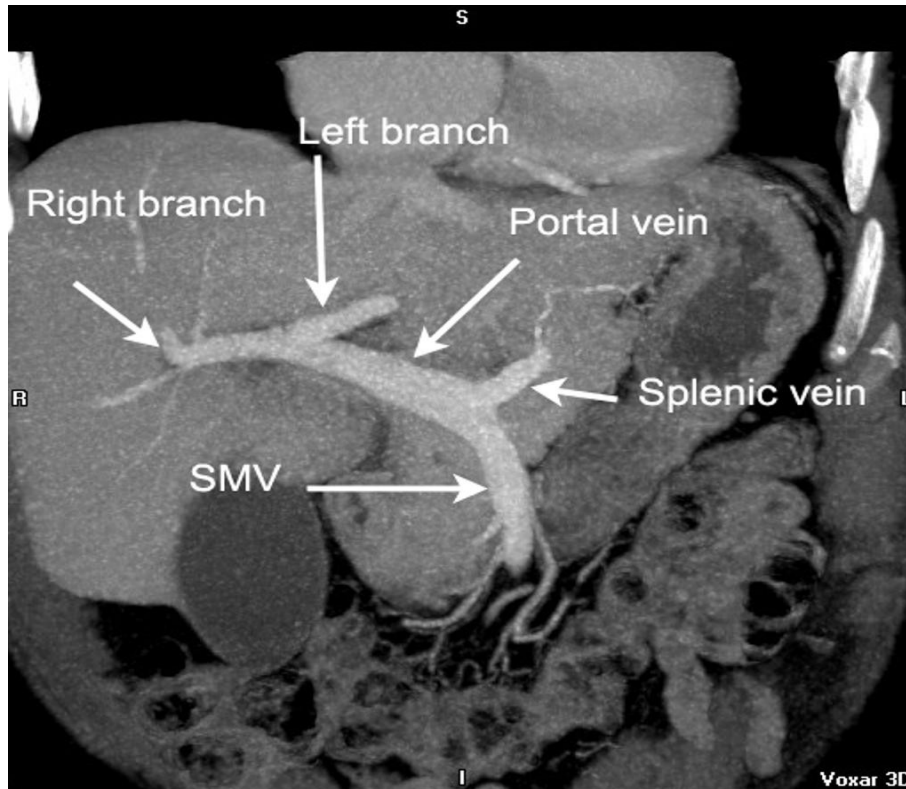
Coronal CT abdomen Porto-venous phase.
